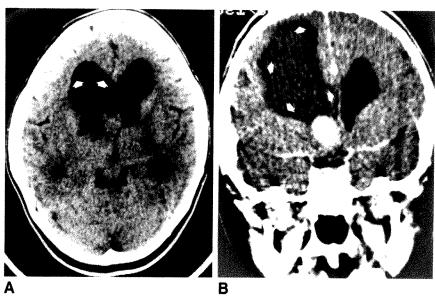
Nonenhanced axial (A) and enhanced coronal (B) CT scans show intraventricular pilocytic astrocytoma. Large associated intraventricular cyst (arrows) has a CT attenuation number slightly higher than that of CSF.
